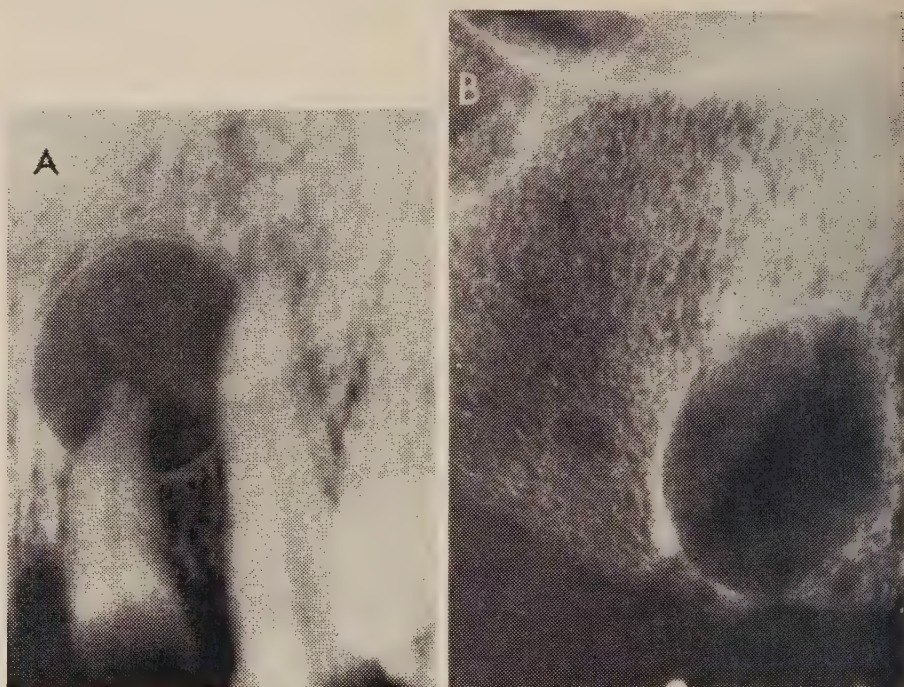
(r.) Three radiographs showing the main change of radiolucency but with variations in the shape, edge, cortication and internal structure. A, In this case the shape is circular, the edge is definite, and there is cortication. Such an appearance suggests a radicular (dental) cyst. B, A radiolucent zone which is roughly oval in shape, has a definite edge and is corticated in some of its outline. This appearance is more probably caused by a benign tumour. C, An irregular shaped radiolucent zone with a definite, in some areas corticated, outline. Structure can be observed within the zone of radiolucency. This is an ameloblastoma.
